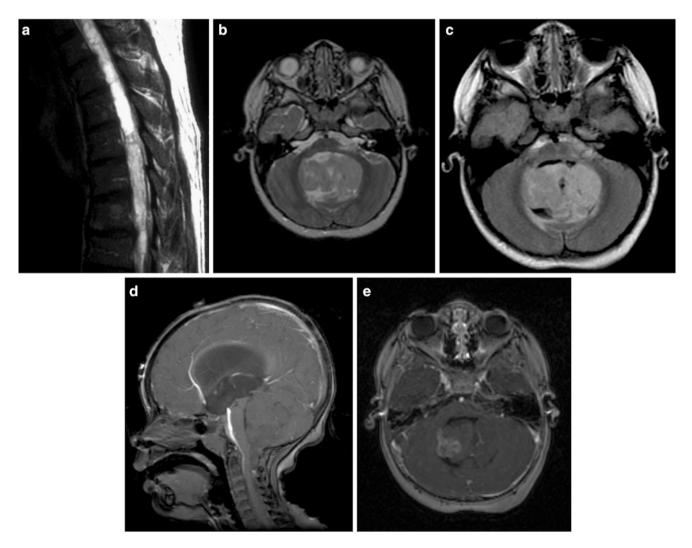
(A) Sagittal TI-weighted post-Gd image of a well-demarcated spinal ependymoma with characteristic homogeneous postcontrast enhancement. (B) Axial MR images of a fourth ventricular ependymoma show a predominantly solid, well-demarcated tumor that has heterogeneous signal characteristics, being isointense to hyperintense
